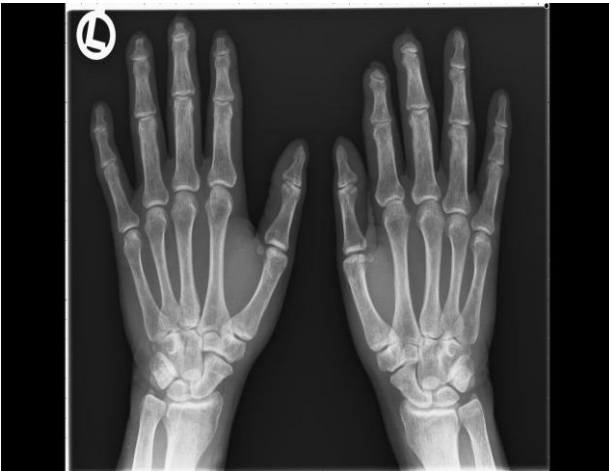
Hand X-ray of the same patient, presented at Fig. 22. Acroosteolysis of the distal phalanges, the most profound of the 2nd and 3rd right fingers is demonstrated.
